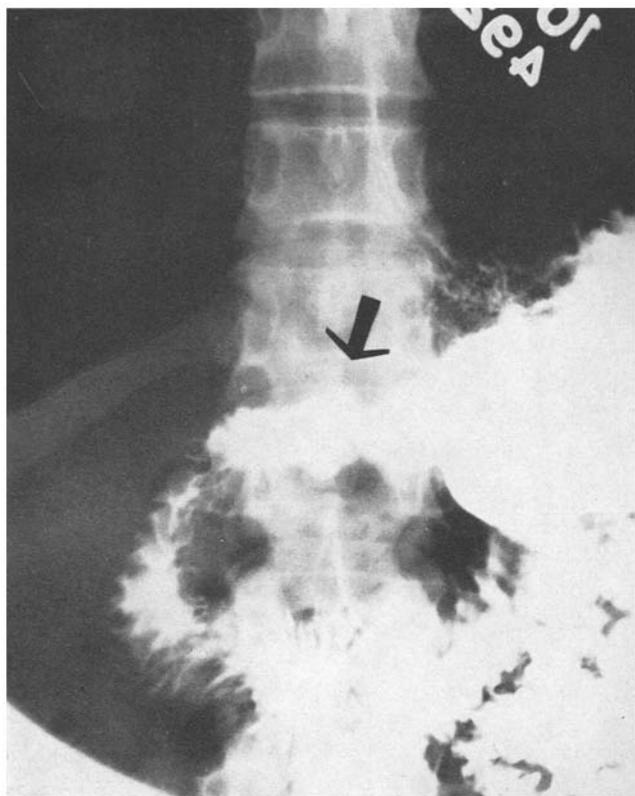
A roentgenogram of the pylorus showing the typical "toadstool" or "umbrella" sign of prolapsed gastric mucosa (Case No. 1).
